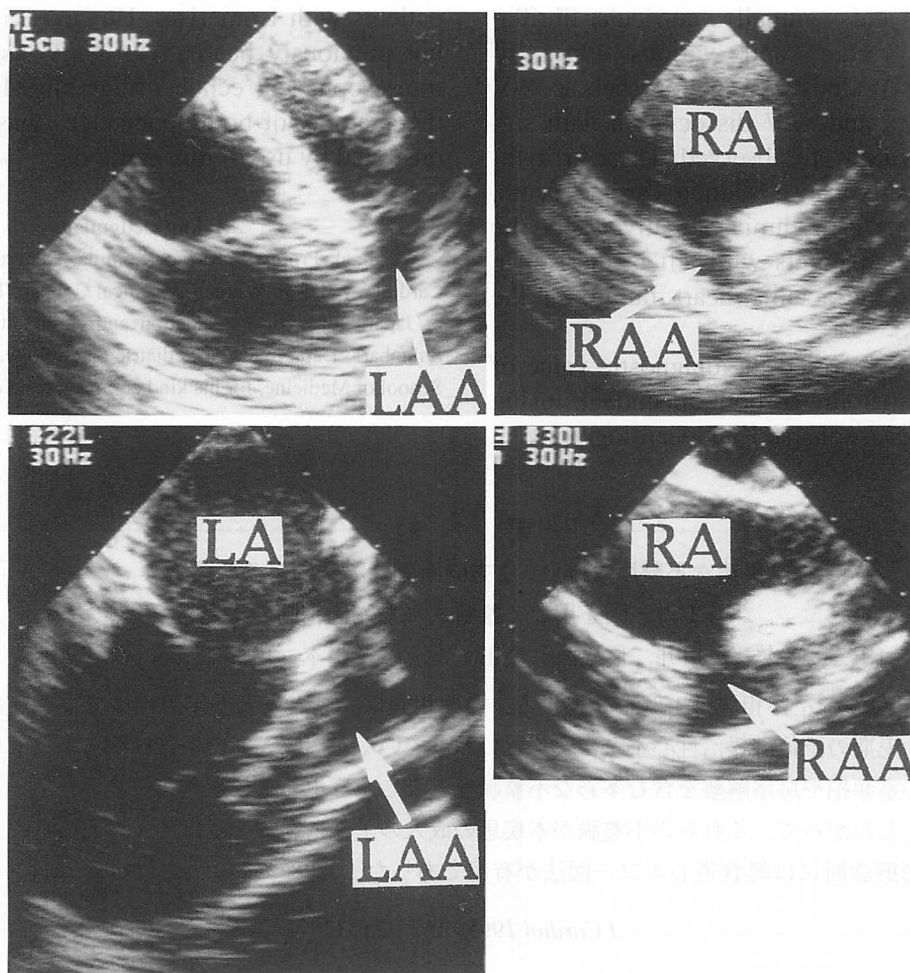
Biplane transesophageal echocardiograms, transverse (*upper*) and longitudinal (*lower*) views
